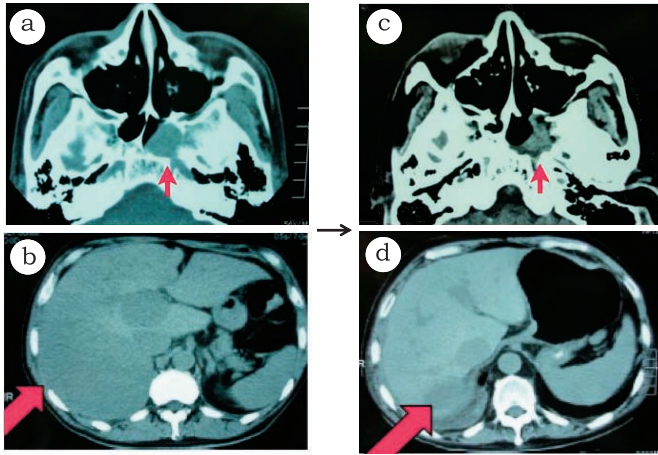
Comparison of computed tomography findings before and after treatment with thalidomide. (5a) Before treatment with thalidomide, a mass between the left wall of the nasopharynx and the sphenoid sinus (\leftarrow) was visible. (5b) Before treatment with thalidomide, a mass in the right lobe of the liver and a mass in the porta hepatis (\leftarrow) were visible. (5c & 5d) After treatment with thalidomide, the masses decreased markedly in size (\leftarrow).
